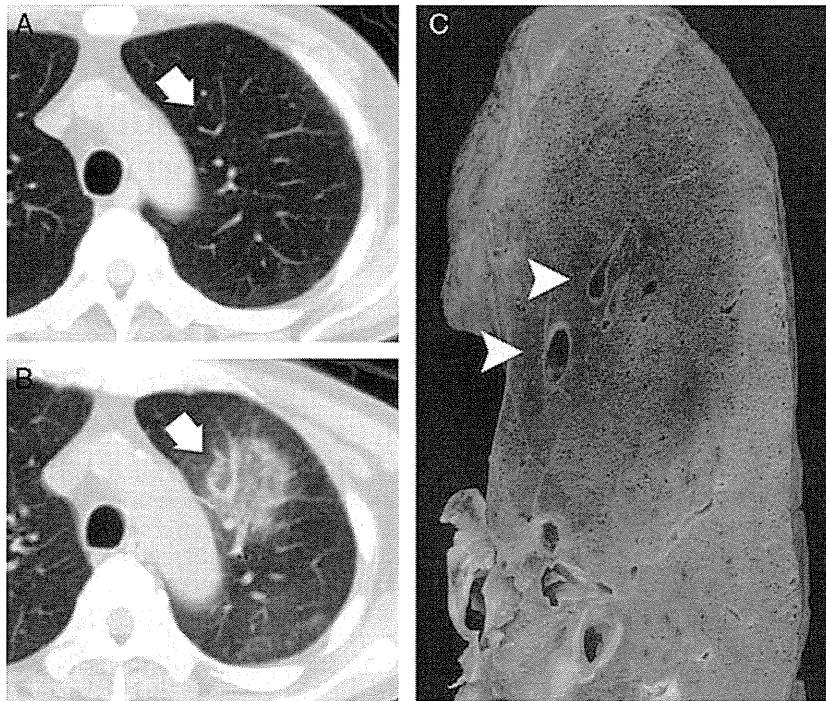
Irregular pulmonary vein dilation (case 1). A, Chest CT scan taken 8 months before the last admission shows normal pulmonary veins (arrow) in the upper lobe of the left lung. B, Chest CT scan taken during the last admission shows irregular pulmonary vein dilation (arrow) surrounded by ground-glass opacity. C, Pulmonary venous invasion is surrounded by hemorrhage at autopsy (arrowheads).
